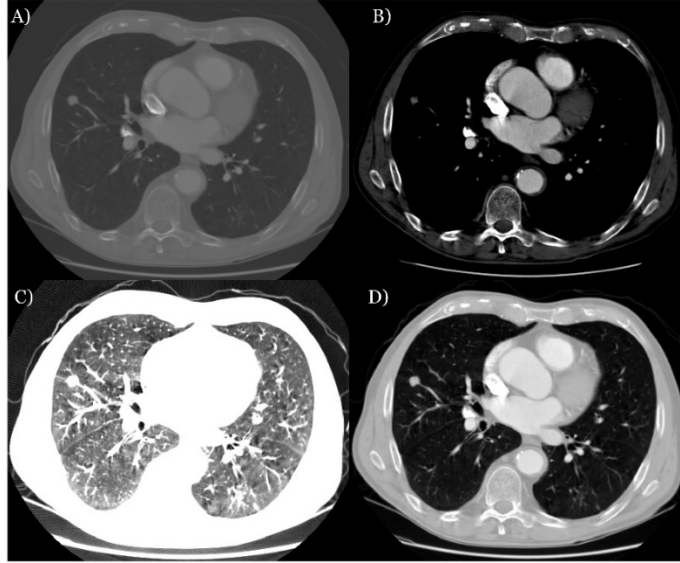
Modification of CT grayscale components by histogram windowing. Visualization of the same slices with intensity range of: A) the originally acquired range [-2000,3000]; B) [-100,500]; C) [-1000,-700]; and D) [-1000, 500].
